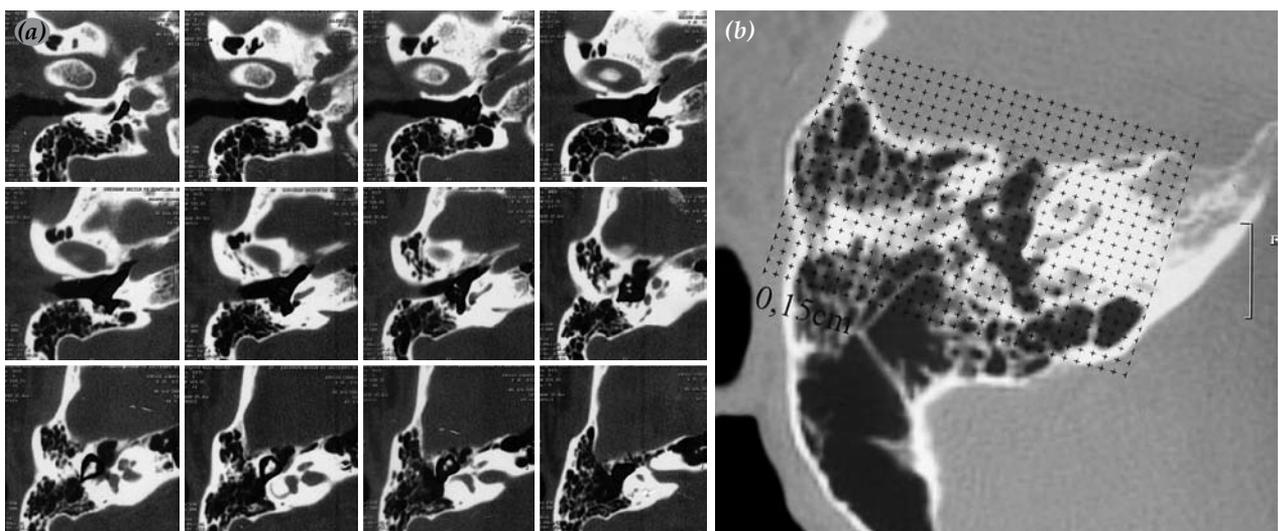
(a) Computed tomography images of the right tympanic cavity in the axial plane. (b) Computed tomography scan (1 mm section) showing volume of tympanic cavity, the technique of counting points has been demonstrated on a axial tympanic cavity section via stereological methods
